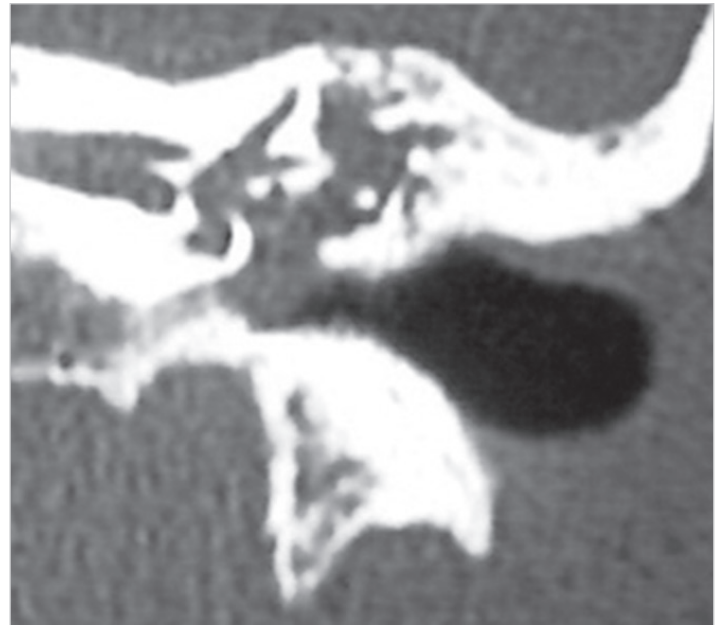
CT scan, coronal view, of the same case. Cholesteatoma fills the middle ear cleft with erosion of the long process of the incus and the suprastructure of the stapes.
